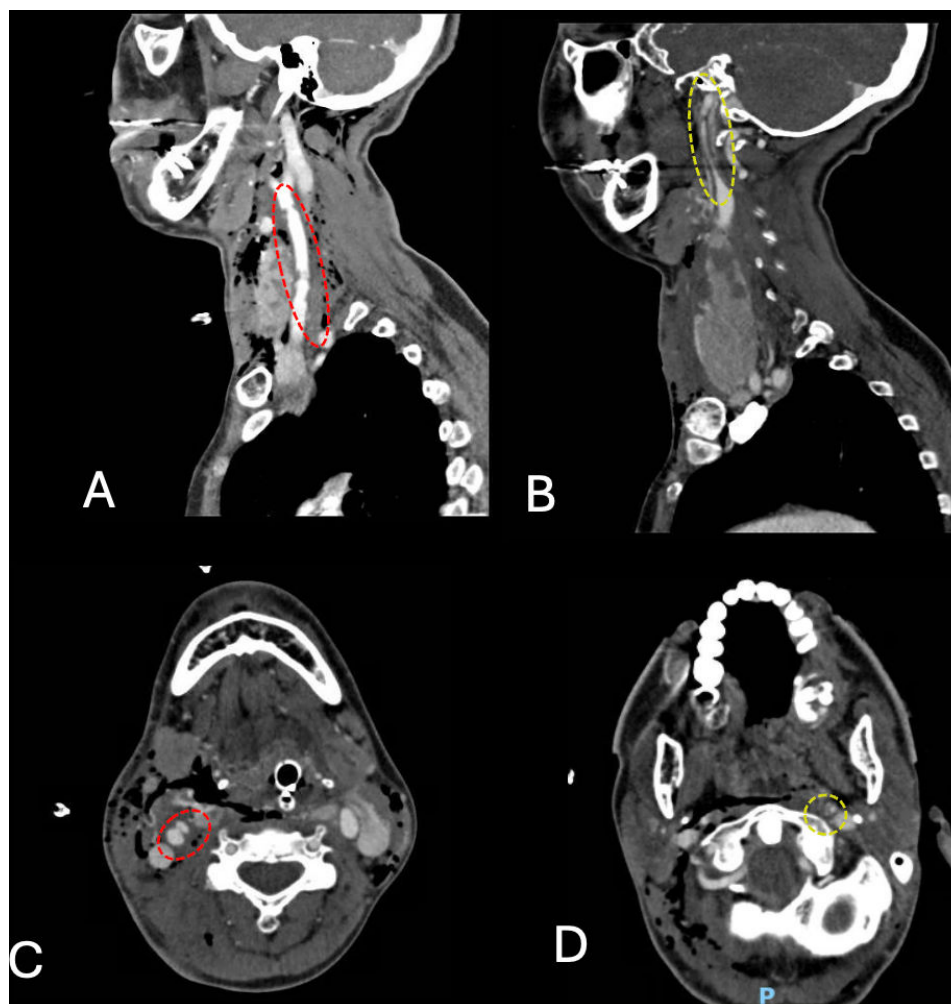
Sagittal (A) and axial (C) CT angiography (CTA) images show a right common carotid artery dissection (circled in red), evidenced by intimal irregularity. Additional sagittal (B) and axial (D) CTA images demonstrate a left internal carotid artery dissection (circled in yellow), featuring a long segmental dissection with potential occlusion of the distal cervical portion near the vertical petrous segment.
